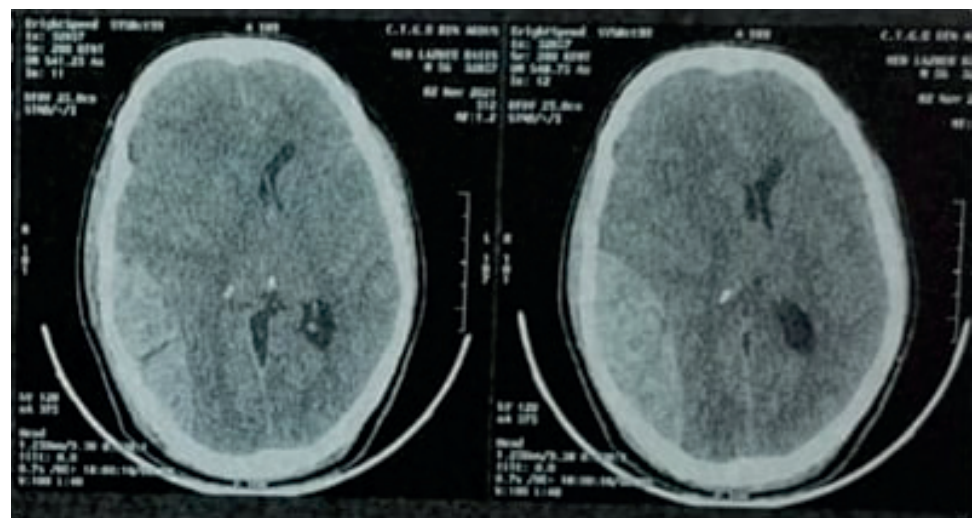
Axial section of a brain computed tomography scan showing a right supratentorial infratentorial epidural hematoma mainly located on the occipito-parietal region.
